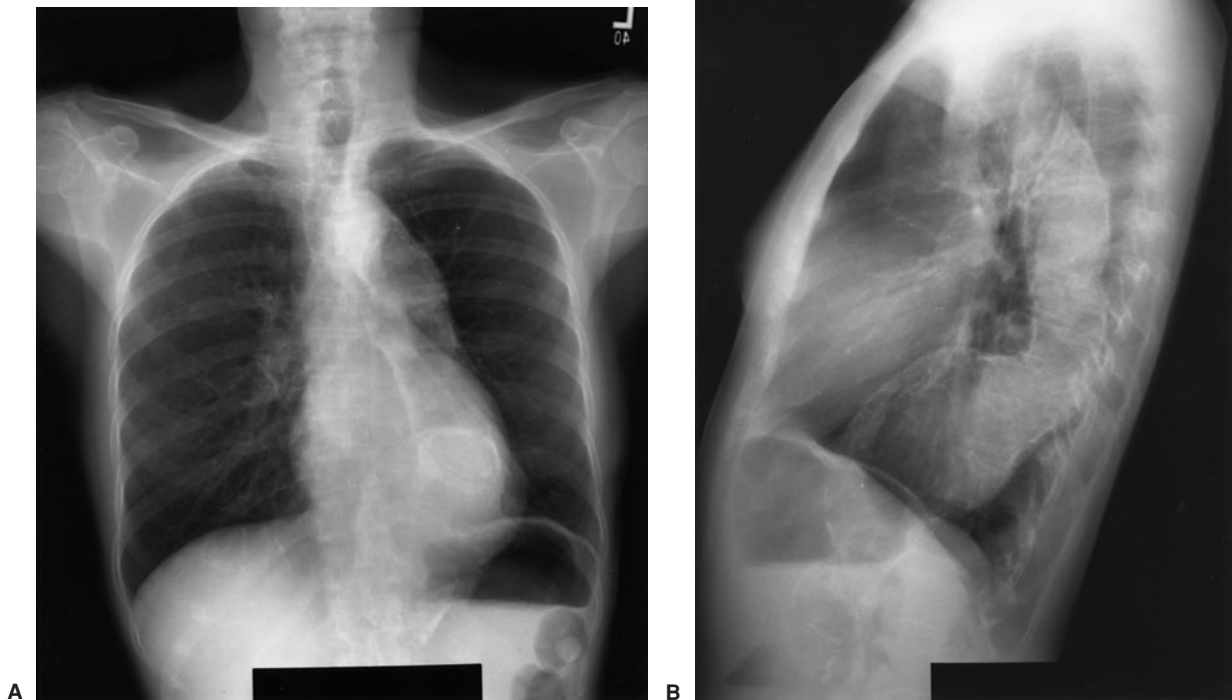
Chest radiographs in (A) posteroanterior and (B) lateral projections showing the calcified wall of a thoracoabdominal aortic aneurysm.
